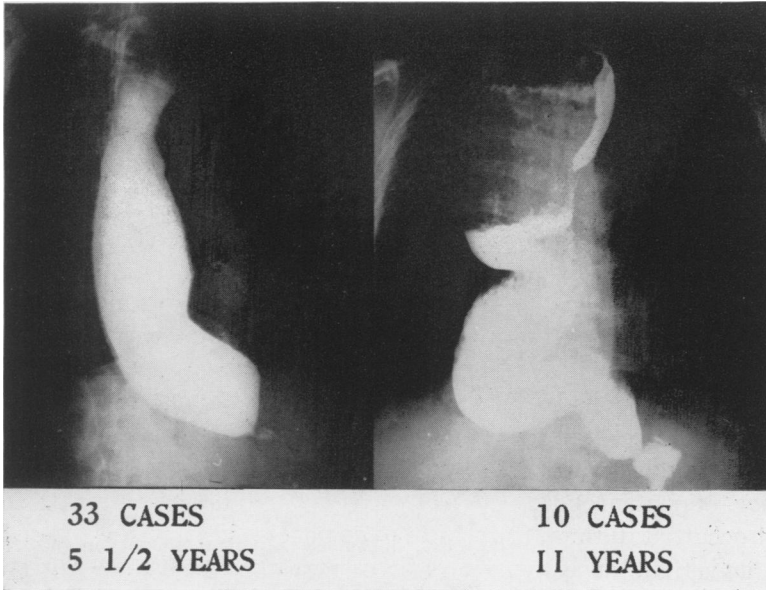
Examples of the two radiographic types of dilatation. Symptoms were present an average of 5½ years in the concentric type, 11 years in the sigmoid type.
